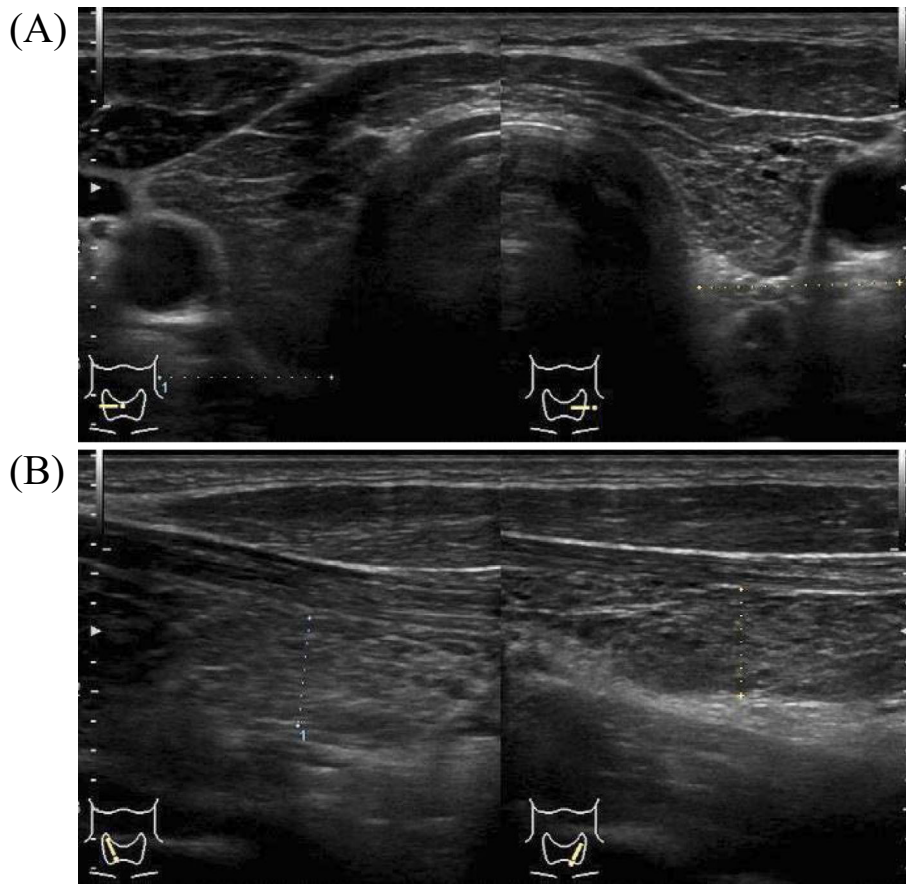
Thyroid ultrasonography (USG). USG shows heterogeneous echotexture mixed with diffuse hypoechoic areas in the thyroid gland.
